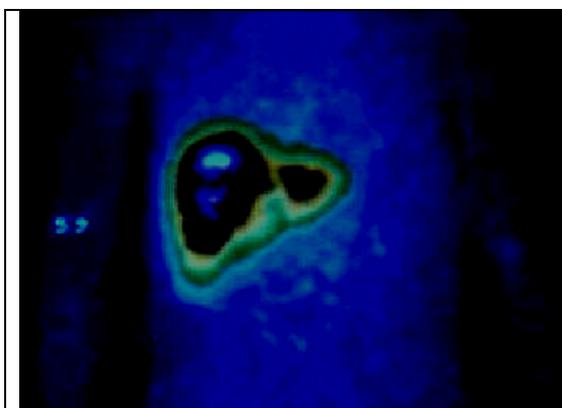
Dynamic scintigraphy of a liver with ^{99m}Tc -labeled imidodiacetic acid. Histogram: 1 - heart area; 2 - liver area; 3 - area of a small bowel. Distribution of RP on scintigram and not lifting of the curve over the area of a small bowel indicates the obstruction of bile duct.
